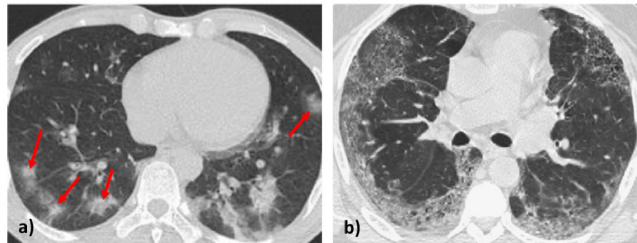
(a) represents a CT of the lungs of a patient with COVID-19, in which there are traces of ground glass opacity indicated by red arrows. (b) shows a CT of the lungs of a non-COVID-19 patient with diffuse opacity in the outer parts of the lungs. These images are courtesy of [35].
